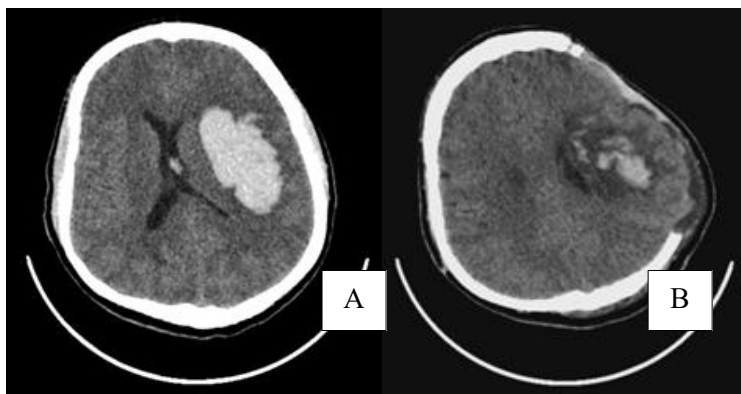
CT scan images. (A) Pre-operative, showing left frontotemporoparietal ICH and intraventricular extension. (B) Post-operative, after craniotomy, decompression and evacuation.
